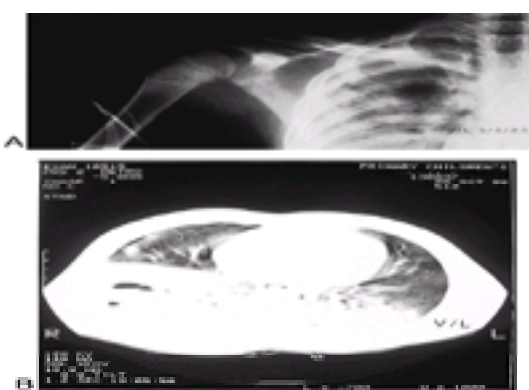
A 7-year-old involved in an auto–pedestrian accident. Crepitus and decreased breath sounds were noted on the right side. Chest radiograph (A) shows rib fractures, clavicle fracture, and a pulmonary contusion. A pulmonary contusion and a pneumothorax are seen on the thoracic computed tomography (B).
